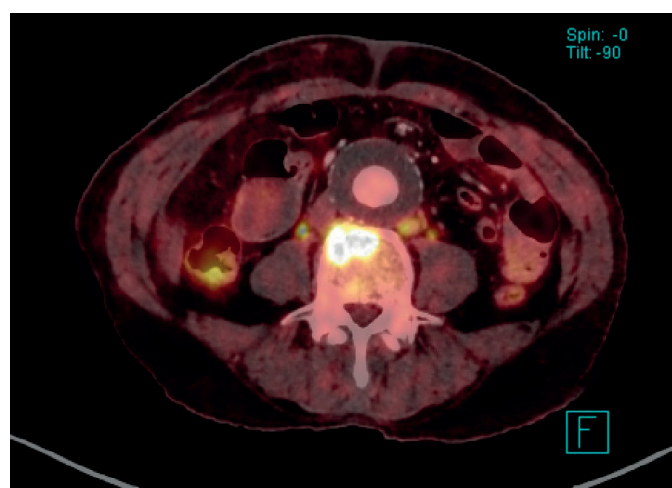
AAA and osteolytic metastasis in the vertebral body (PET CT).
